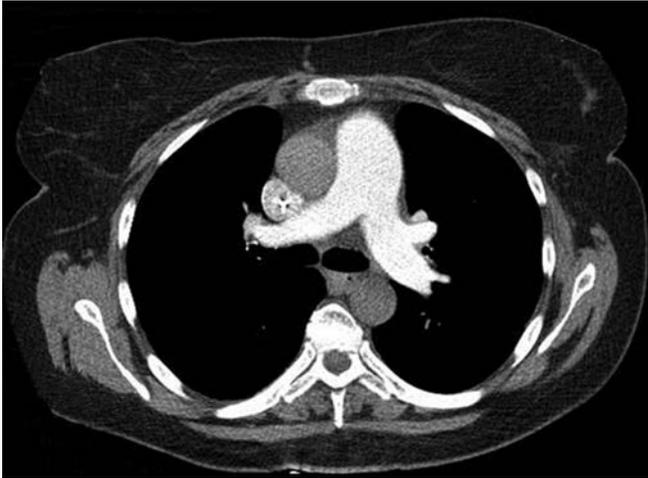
Chest CT with contrast, showing no central or segmental pulmonary emboli.
